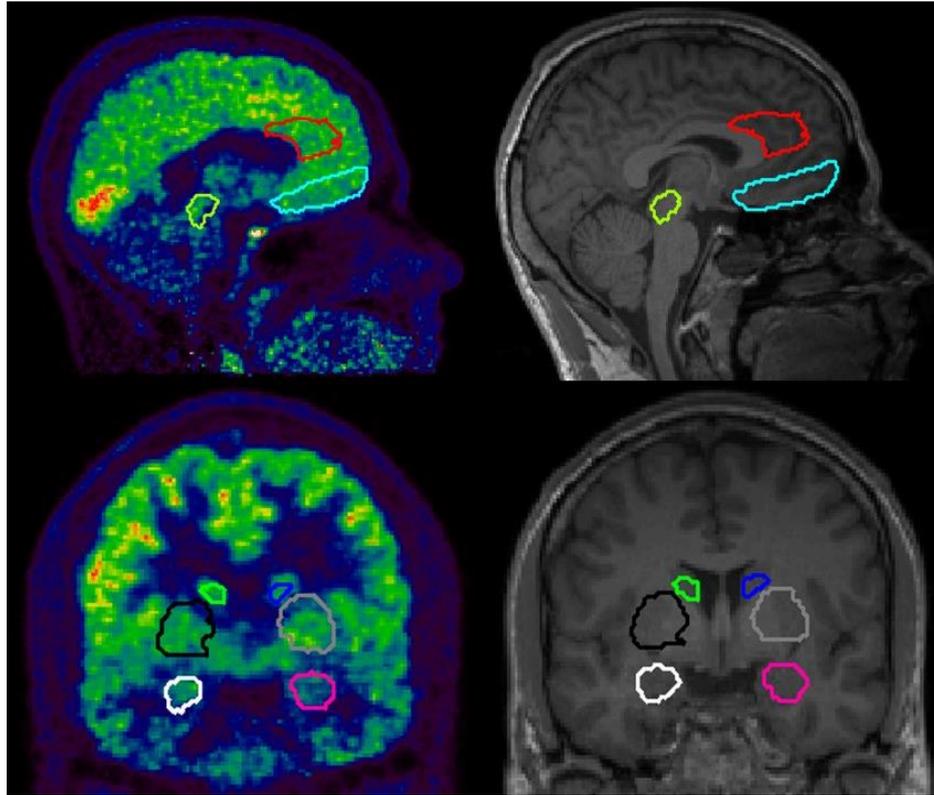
Volume of interests (in study 2 and 3) delineated on a [^{11}C]AZ10419369 PET image (left) and on an MRI (right). Striatum: black/grey/green/dark blue, Amygdala: pink/white, Raphe nuclei: yellow, Orbitofrontal cortex: light blue, Anterior cingulate cortex: red.
